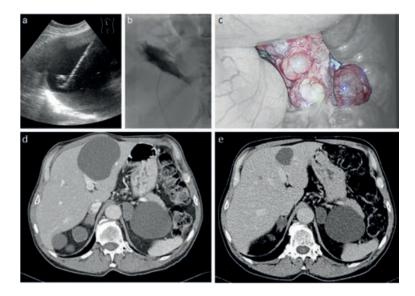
Aspiration sclerotherapy overview. (a.) ultrasound image of intracystic catheter. (b.) x-ray image of intracystic contrast medium; no leakage is revealed. (c.) photo of a sclerosed cyst during laparoscopy, other tissues in grayscale for clarity. Notice the irregularities due to scarring. (d.) CT-scan image of a hepatic cyst before and (e.) after aspiration sclerotherapy.
